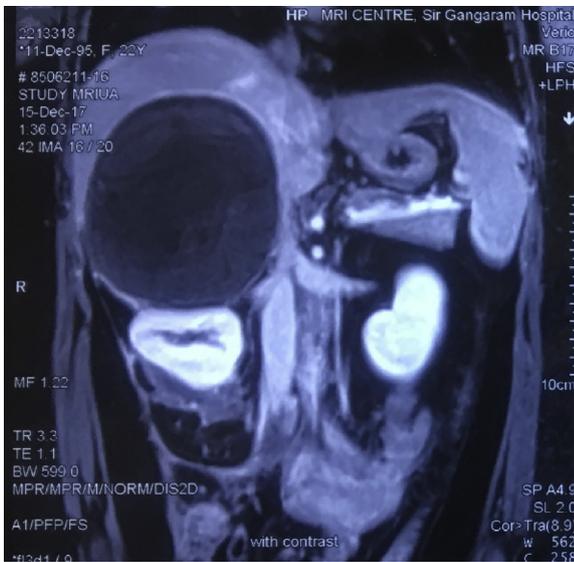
Abdominal MRI showed a lesion of 9.35 cm in diameter in the right suprarenal region. The lesion is indenting upon the inferior surface of hepatic parenchyma and displacing the kidney anteriorly and inferiorly. MRI, magnetic resonance imaging.
